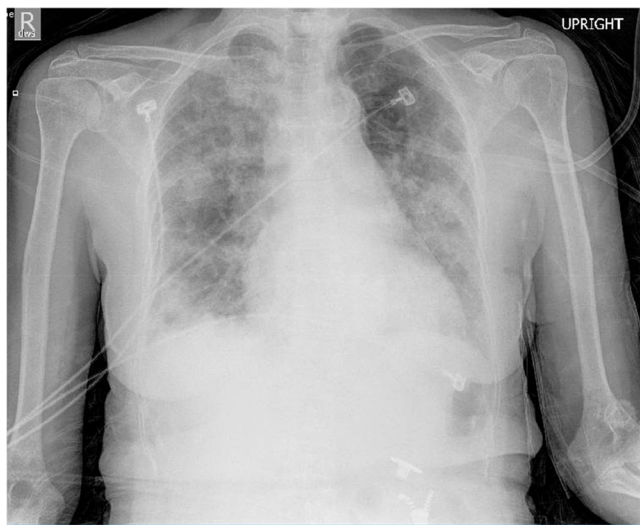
Chest x-ray showing bilateral multifocal patchy airspace opacities
